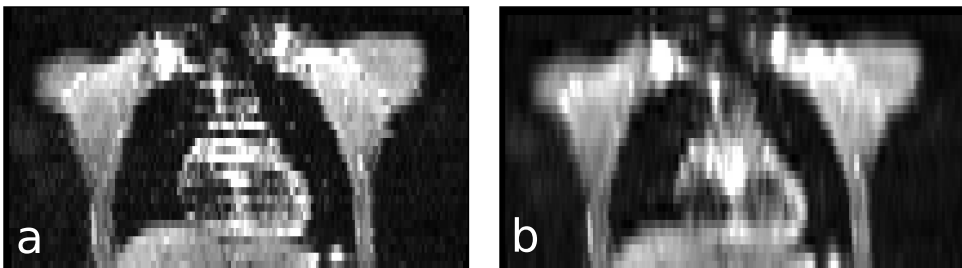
(a) Original DW-MRI coronal view of a patient ($b = 0 \text{ s/mm}^2$). Note the artefacts between odd and even slices, deriving from the interleaved and free-breathing acquisition. (b) Same DW-MRI after motion compensation.
